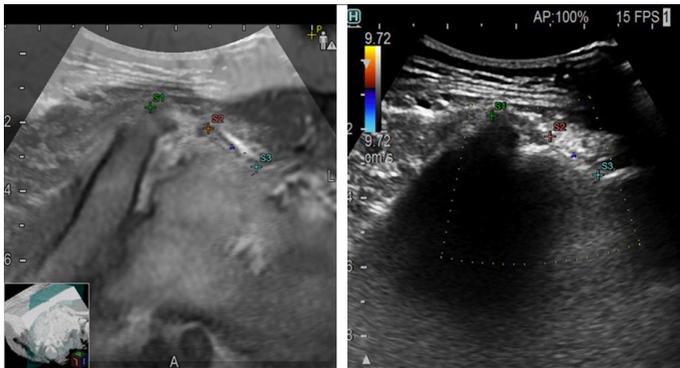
Plane and point registration at the level of 2nd sacral foramen for synovial injections. Magnetic resonance imaging on the left and real-time ultrasonography images on the right are matched by placing S1, S2 and S3 points.
